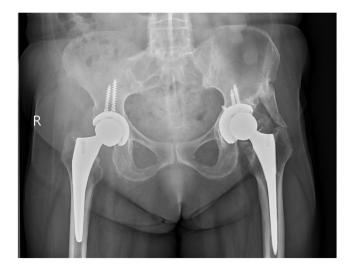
Postoperative 6-mo radiograph of case 2 showing good alignment with no heterotopic ossification on the right side with robotic THA.
